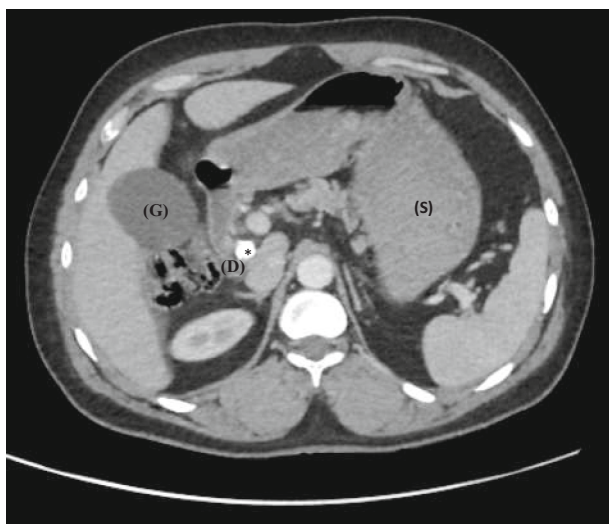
Abdominal computed tomography (CT) scan reveals the presence of a 1.8 cm gallstone (*) in the gallbladder infundibulum with mild parietal contrast intake (G) compressing the duodenal bulb (D) associated with prominent gastric distention (S).
